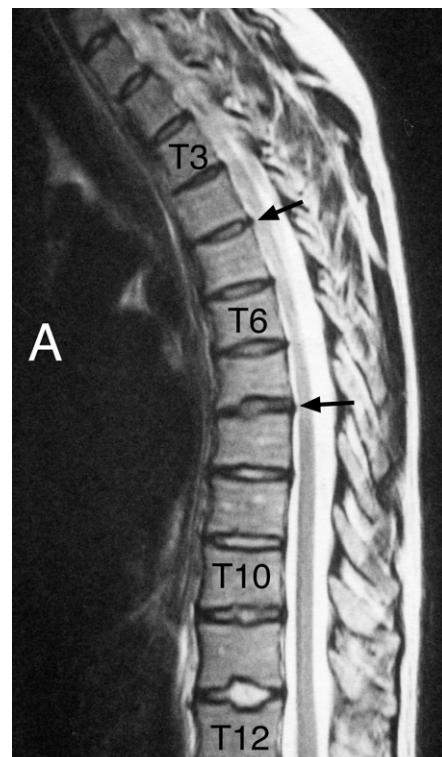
Thoracic spine MRI T2-weighted sagittal image. Note (i) the 'minor posterior bulging' of discs 'in the mid to upper thoracic spine' (black arrows), (ii) early desiccation of these discs indicating that these changes are not of longstanding, (iii) the very slight irregularity of the superior endplate of T11 centrally, and (iv) Schmorl's nodes centrally to posteriorly in the endplates adjacent to the T11–12 disc. There is no evidence to suggest Scheuermann's disease. A = anterior (front) side of patient.
